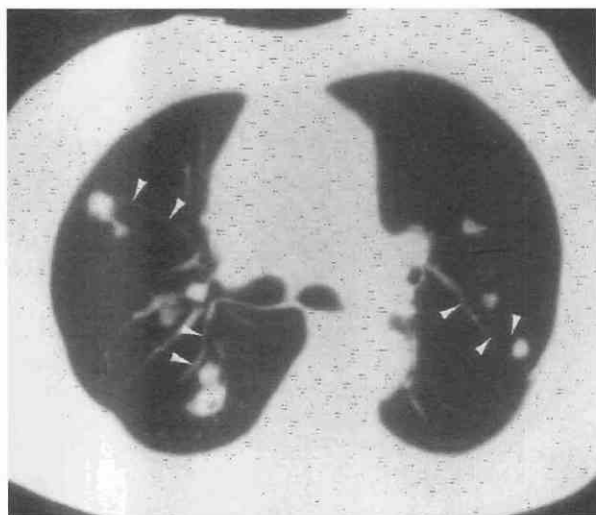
Hematogenous metastases. CT shows multiple pulmonary nodules, each with a discrete feeding vessel leading to it (arrowheads). (From Kuhlman JE: CT of diffuse lung disease. Appl Radiol 20:17-21, 1991.)
